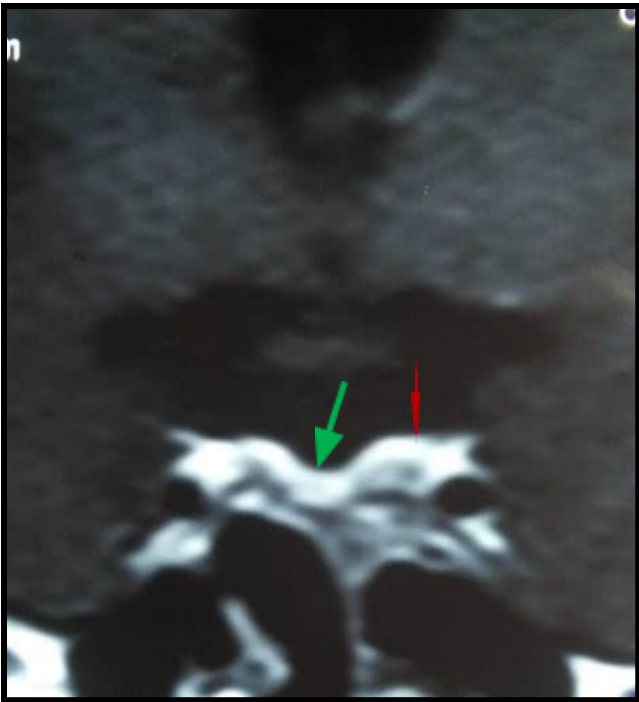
Post-operative pituitary MRI of patient
